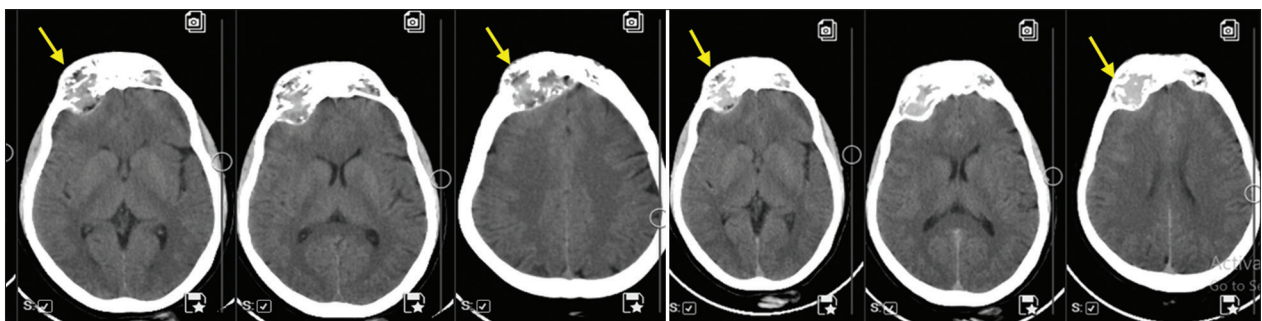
Axial non-contrast computed tomography (soft-tissue window) images show a well-defined expansile diploic lesion in the right frontal bone causing mild indentation of the frontal lobe without cortical breach or soft-tissue extension
